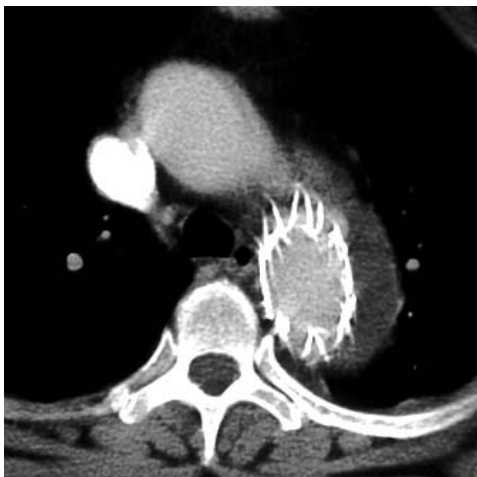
After the successful deployment of stent-graft at primary entry tear, follow up CT scan have shown complete thrombosis of the thoracic false lumen and expansion of true lumen for 5 years.
